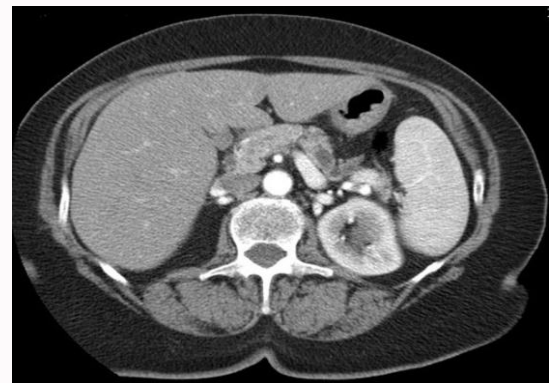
CT showing an intraductal papillary mucinous neoplasm of the pancreatic body.
